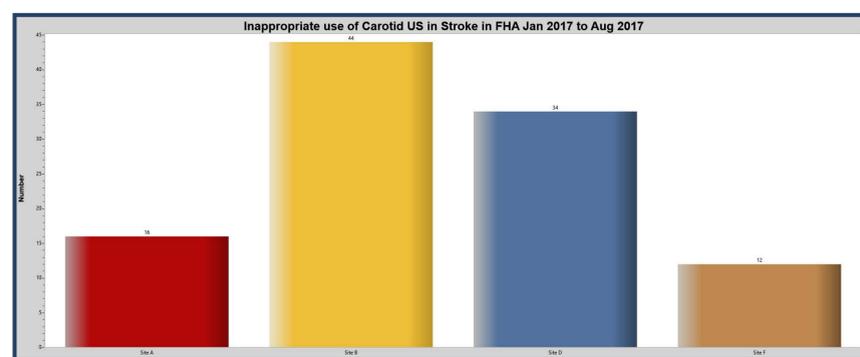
confirms the presence of similar cases where patients are receiving both CT Angio and carotid Ultrasounds without real cause across multiple Fraser health facilities
